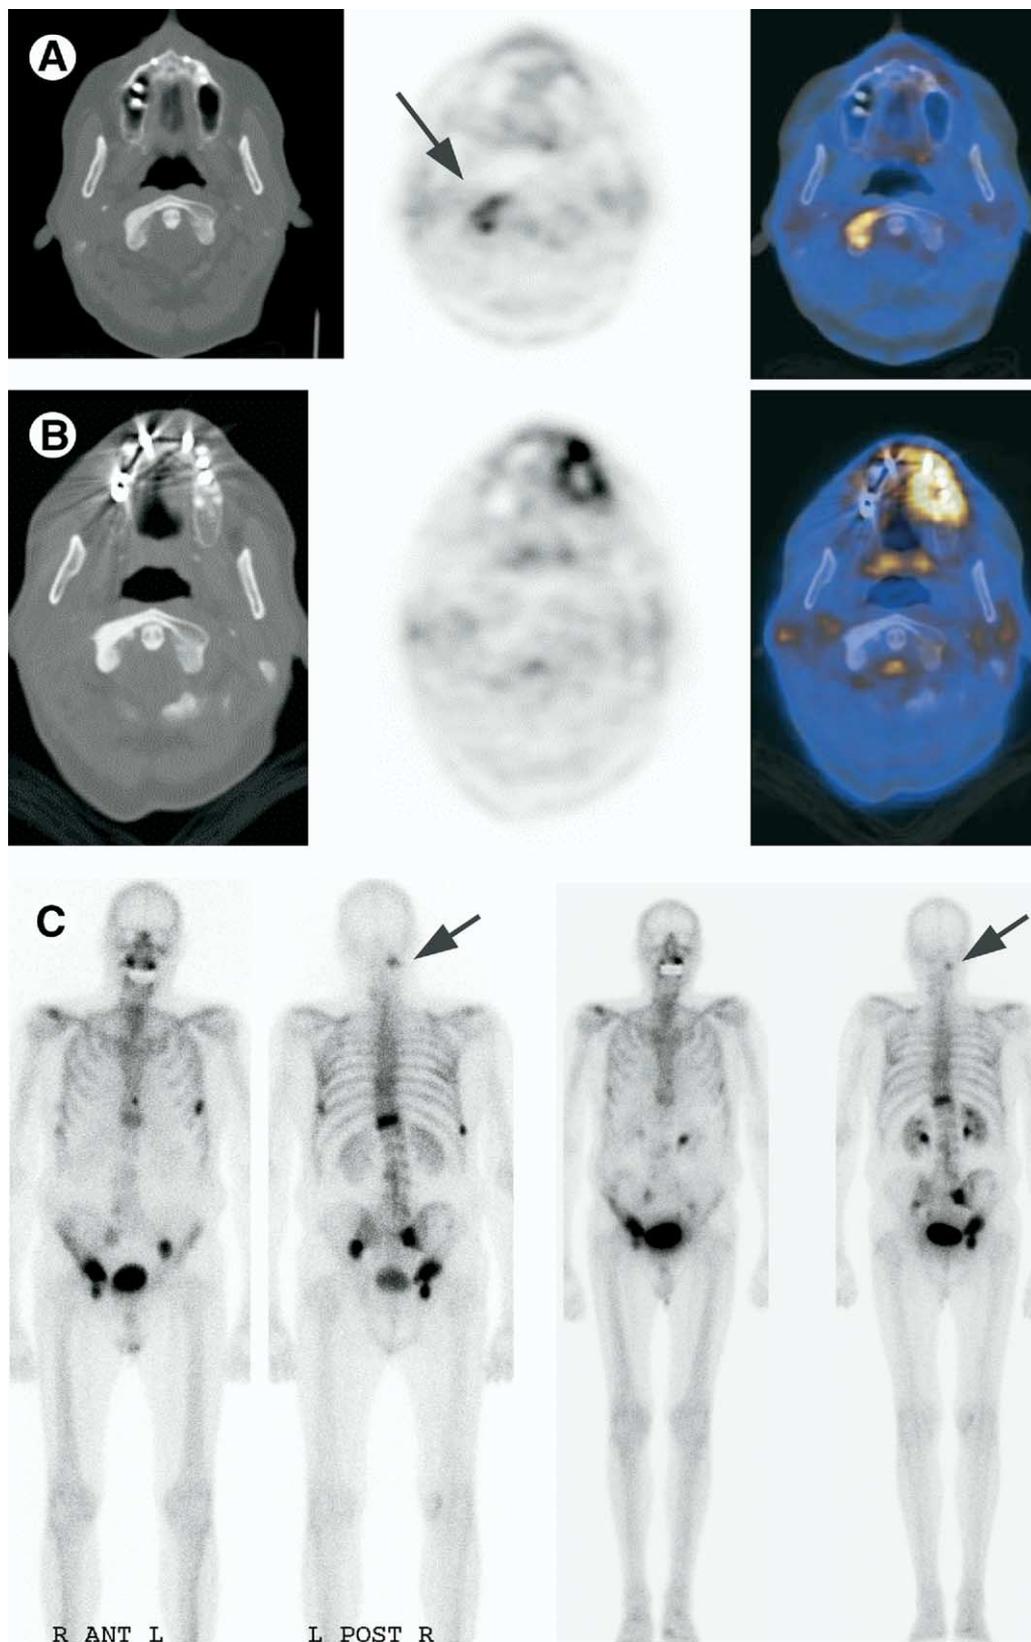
FDG-PET shows response to therapy in this patient with osseous metastases from prostate cancer who had a PSA of 5.88 ng/mL. (A) CT, PET, and PET-CT fusion images show abnormal FDG uptake within a sclerotic lesion in the axis (second cervical vertebra). (B) A follow-up study 6 months later, after combined androgen withdrawal therapy, shows an identical CT image but lack of FDG uptake. (C) Bone scan images at time point 1 (left panel) and 6 months later (right panel) are almost identical with several lesions in spine and pelvis. (Color version of figure is available online.)
